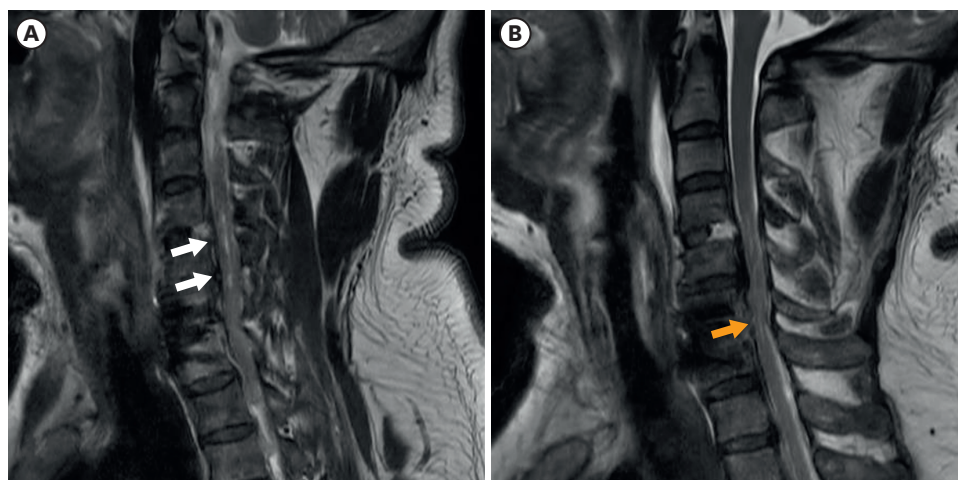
(A) Preoperative sagittal T2 weighted MRI revealing the high intensity signal change on T2-weighted image at C3-5 level (white arrow). (B) Preoperative axial T2 weighted MRI showing significant cord compression (yellow arrow) with malacic change (white arrow) in C3-4 level. MRI, magnetic resonance imaging.
